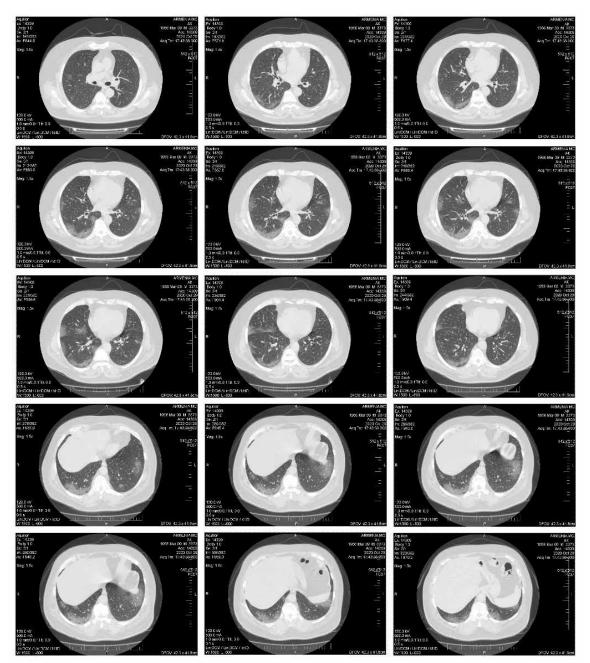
Multislice CT (MSCT) of lungs
